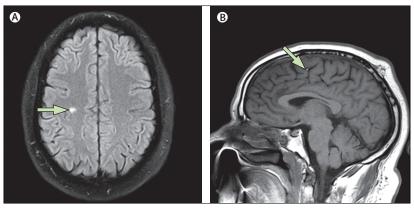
MRI of a patient with cortical hand syndrome
